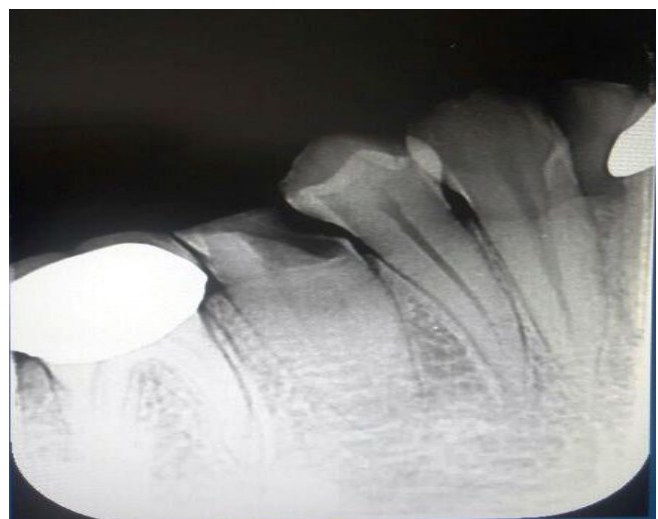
Pre-operative radiographic picture showing two root canals
